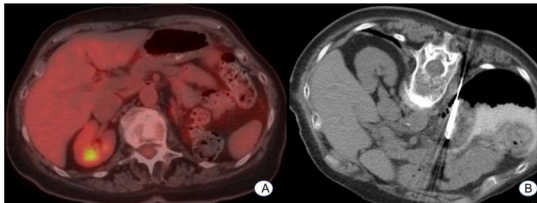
81-year-old female with 1.8 cm biopsy-proven left adrenal metastasis (squamous cell carcinoma) demonstrating mild hypermetabolism on PET/CT (A). Patient underwent CT-guided cryoablation (Galil IceRod) which required preablation hydropneumodissection (2% contrast:saline solution) to displaced the diaphragm and lung (B).
